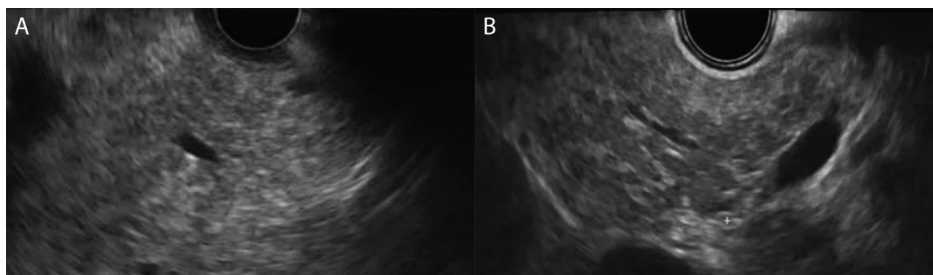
Serial still images of endosonography in a participant with marked progression of features of chronic pancreatitis
